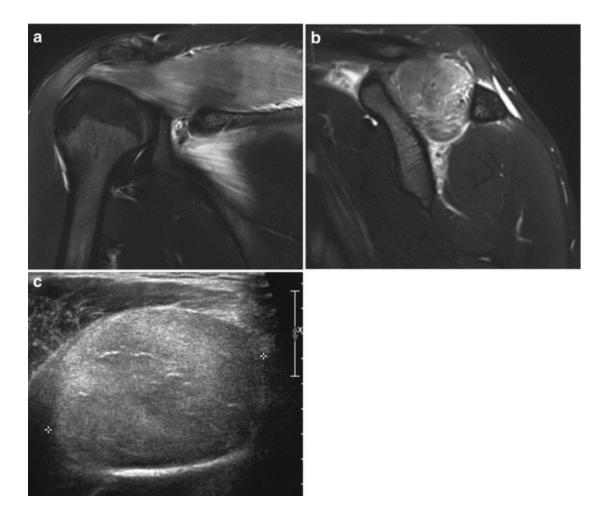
A 20-year-old male patient with overexertion of the upper-arms during exercise in the early afternoon. After a delay of 5 h, the patients reported rapidly progressive pain and disability of the right shoulder. Coronal (a) and sagittal (b) fat-suppressed T2-weighted MRI performed the following day confirm the presence of edema and swelling of the supraspinatus muscle typical of a DOMS syndrome. Transverse ultrasound image (c) confirms both swelling and hyperechoic edema of the muscle
